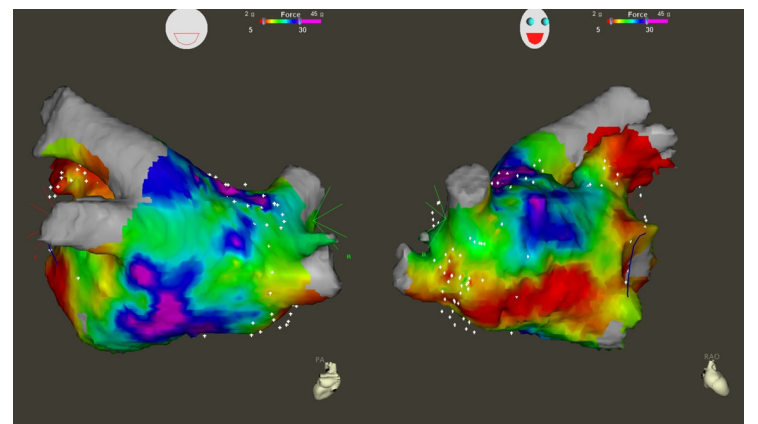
An example of image integration of contact force data in color (2 g lower limit, 30 g upper limit) with CT angiogram of the left atrium and pulmonary veins. Left panel shows posterior view and right panel right anterior view. Color scheme depicts typical distribution of contact forces with the highest values in the region of the roof and upper septum (where aortic root overlies the atrium).
